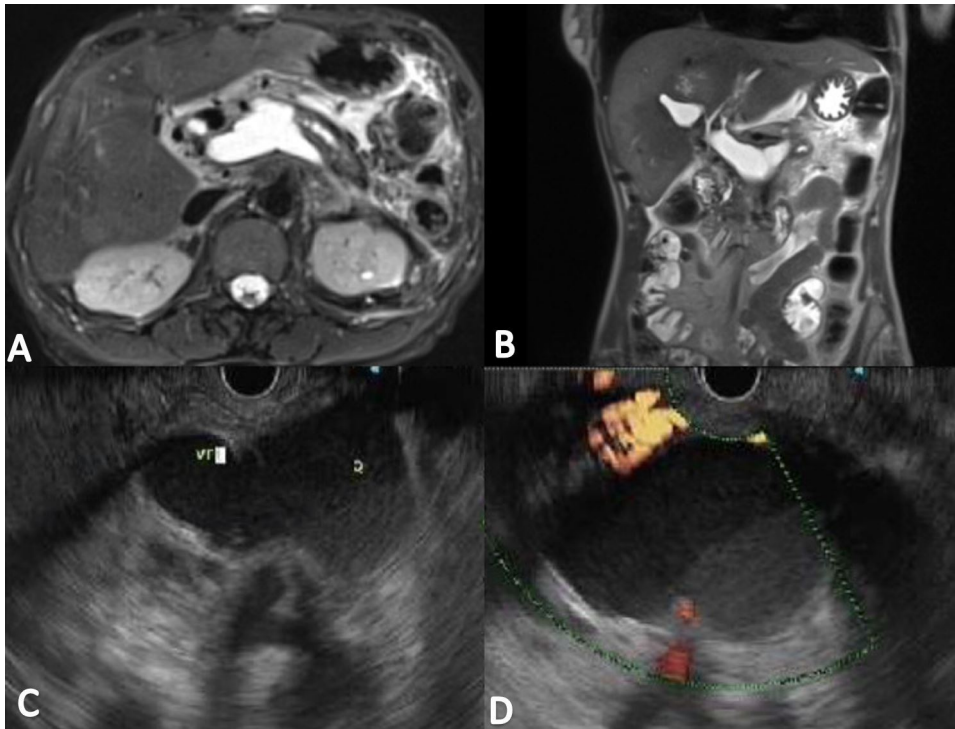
A-B: T2-weighted MR images showing a pseudocyst in the head region of the pancreas with fluid signal intensity extending to the main portal veins and several intrahepatic branches. C. EUS image showing the portal vein connected to the pancreatic pseudocyst. D. EUS image showing no detectable flow in the portal vein on Doppler mode.
